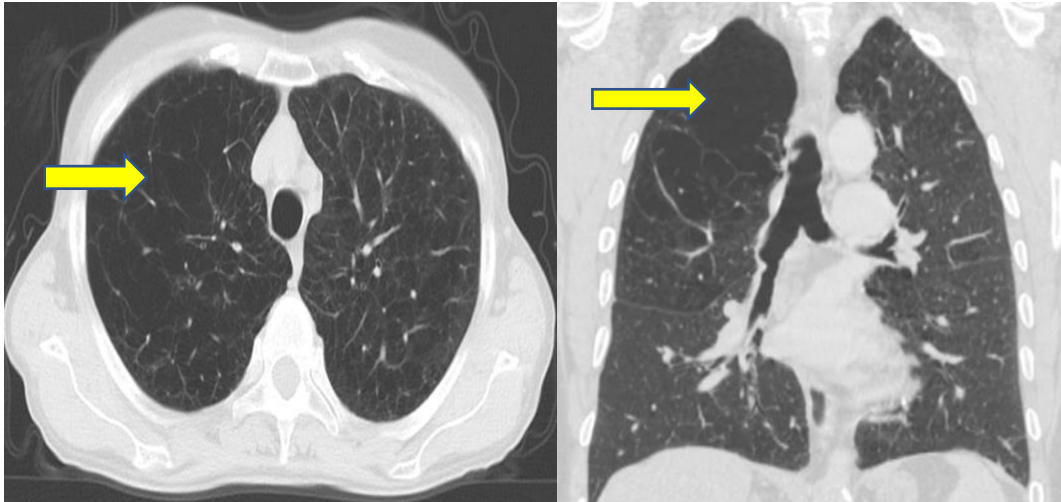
CT scan of a patient at Liverpool Heart and Chest Hospital, demonstrating right upper lobe emphysema (yellow arrow)
